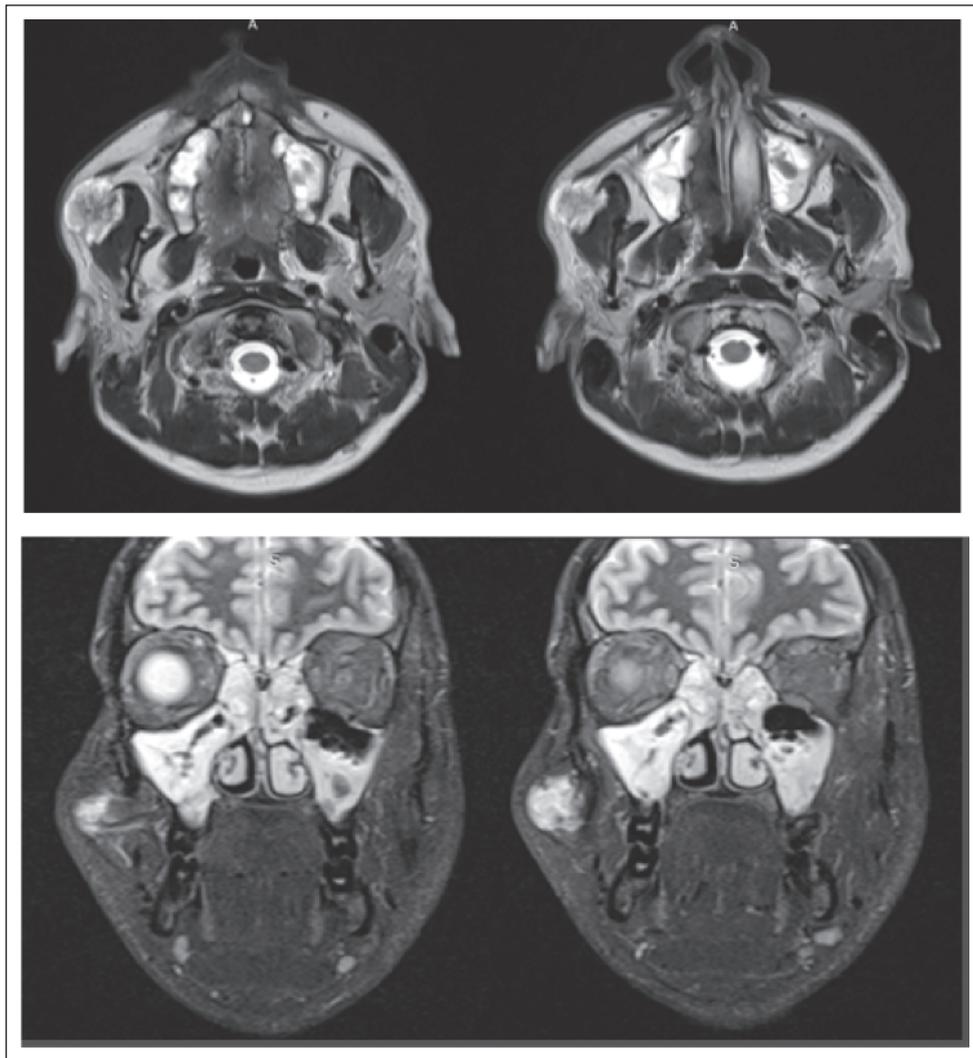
MRI images from axial view (upper) and coronal view (below). Noted the mass is blended with the right Stensen's duct.
